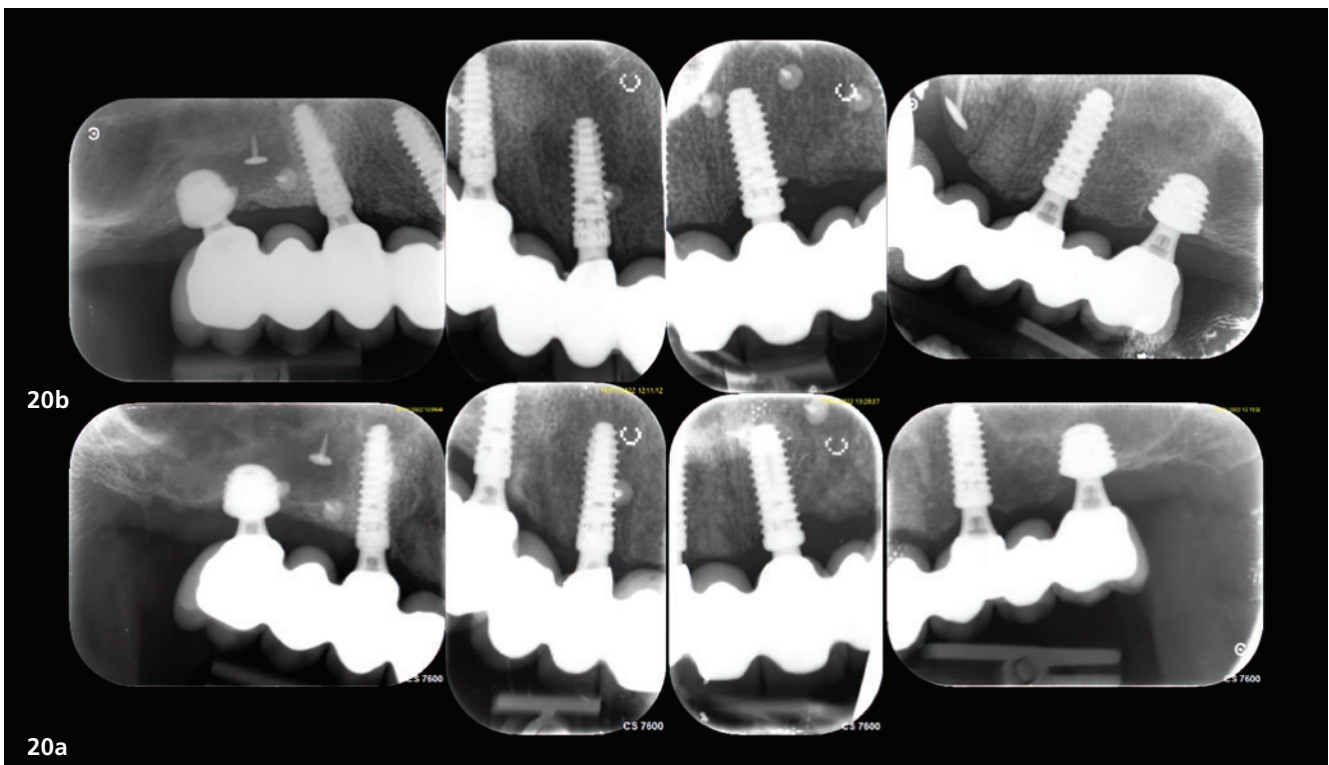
Definitive restoration. Fig. 19: Patient's smile. Figs. 20a & b: Intra-oral radiographic status (a) at the end of treatment and (b) one year later. The marginal bone levels had been maintained, and there was good maturation of the bone all around the implants, especially the ultrashort implants, notwithstanding the reduced height of the native bone at the beginning of treatment.
